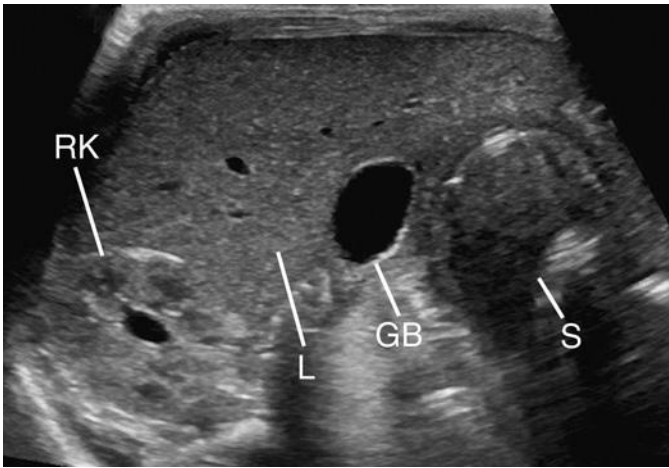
Neonatal abdominal sonogram. Transverse axial image in a 1-month-old infant born premature at 24 weeks' gestation demonstrates the right kidney (RK), liver (L), gallbladder (GB), and stomach (S).
